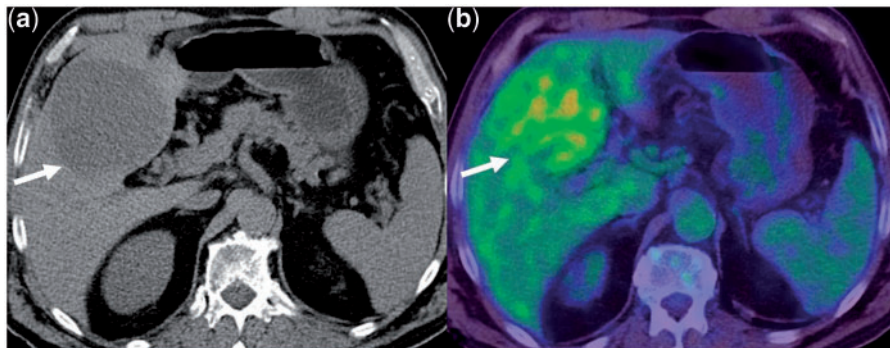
Unenhanced CT (a) and fused PET/CT image (b) of an FDG-avid moderately differentiated HCC (arrow).
